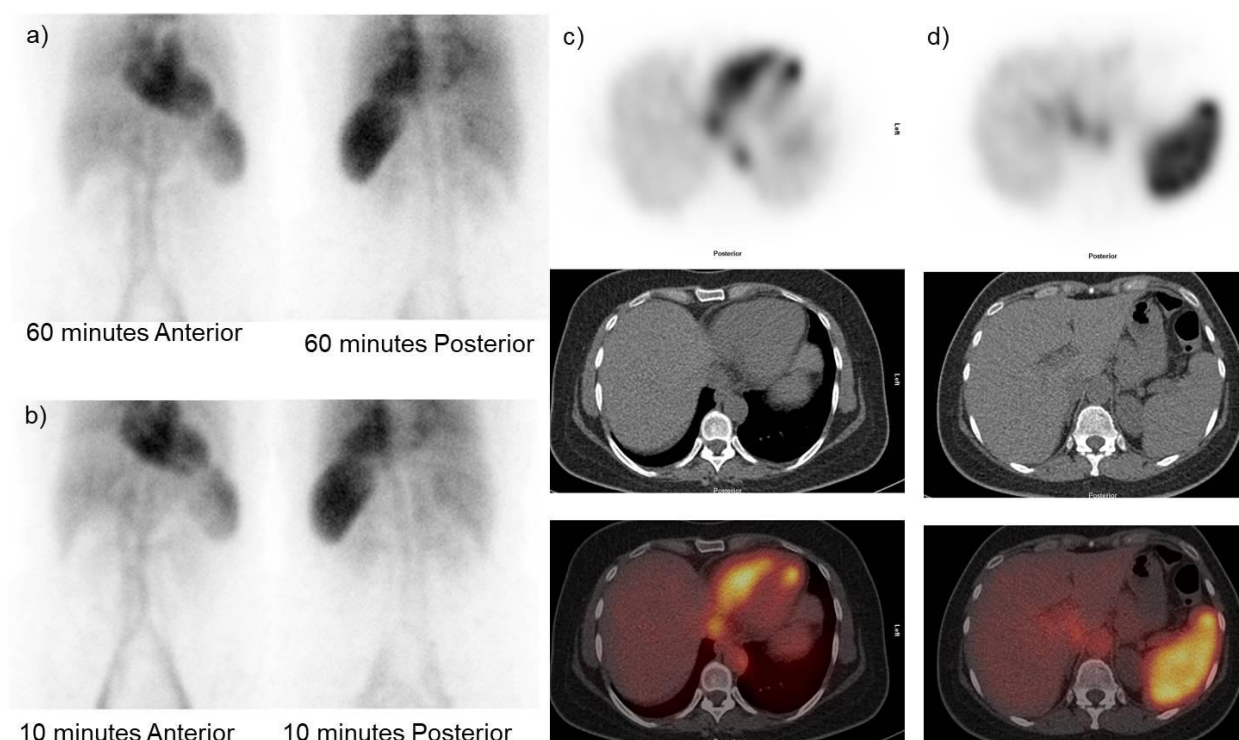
^{99m}Tc labeled RBC Scan of the Liver a-b) 60 and 10minutes static images c-d) SPECT/CT images
